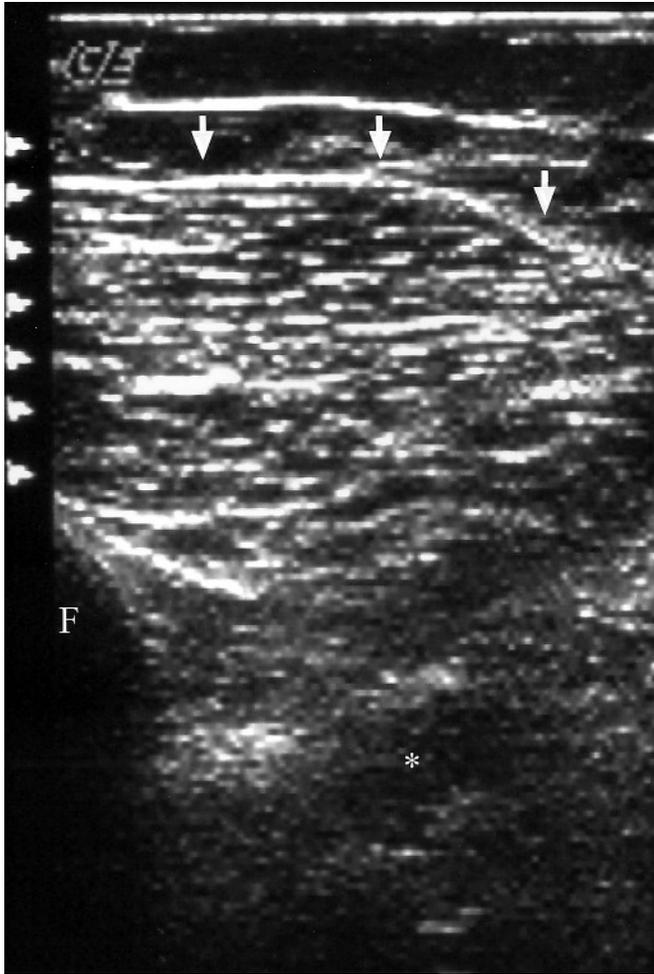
Normal muscle, grade 0. Transverse sonogram of the vastus medialis muscle of a control subject. The muscle is normally hypoechoic (dark), containing thin echogenic (bright) lines corresponding to the perimysial connective tissue. Arrows denote the anterior border of the muscle. F: femur; \*: the neurovascular bundle.
